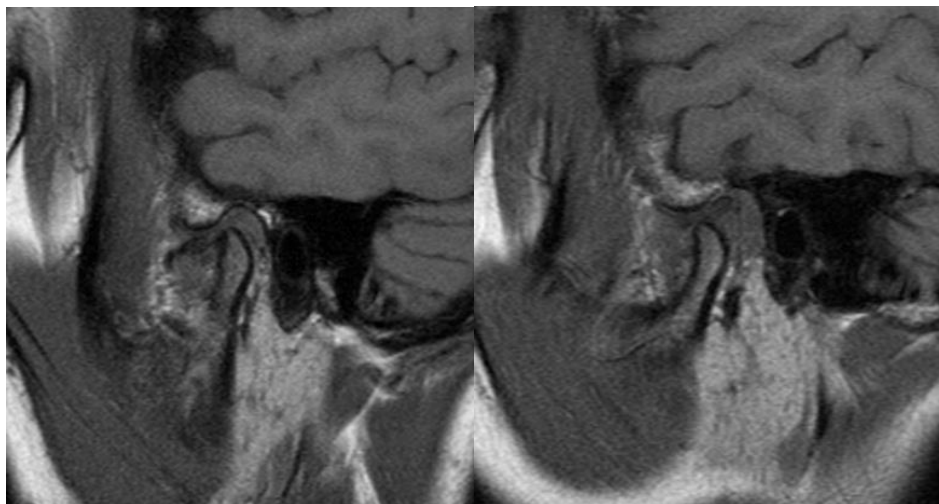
Pre-Treatment Sagittal T1 Weighted MRI in open mouth position show a non reducing disc displacement of right TMJ (a) and reducing disc displacement of left TMJ (b)
